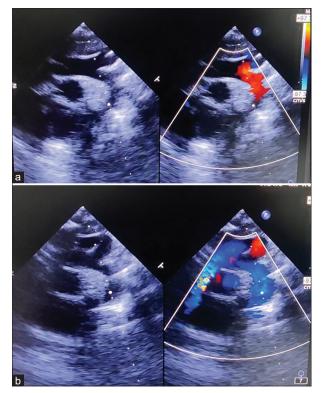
Suprasternal view of aortic arch color Doppler showing arch reversal (a), and no arch reversal (b)
